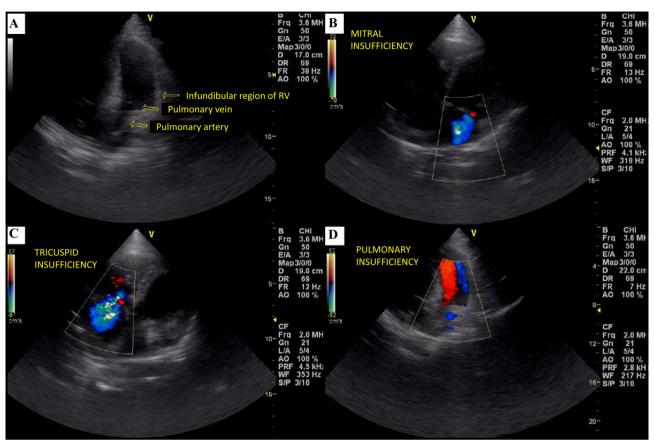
Echocardiography of a 9-year-old male English Bulldog with a history of syncope and postprandial cyanosis. With tachycardia (164 bpm) and an irregular rhythm, the exam revealed a slight increase in the diastolic diameter of the left ventricle (LV), a significant enlargement of the cavity in the infundibular region of the right ventricle (RV, A), and an enlarged right atrium (RA). The mitral valve was thickened with mild insufficiency (B), the tricuspid valve showed significant insufficiency (C), and the pulmonary valve demonstrated moderate insufficiency (D). These findings indicated significant remodeling of the right heart chambers and important tricuspid valve insufficiency, suggesting category III arrhythmogenic right ventricular cardiomyopathy (ARVC).
